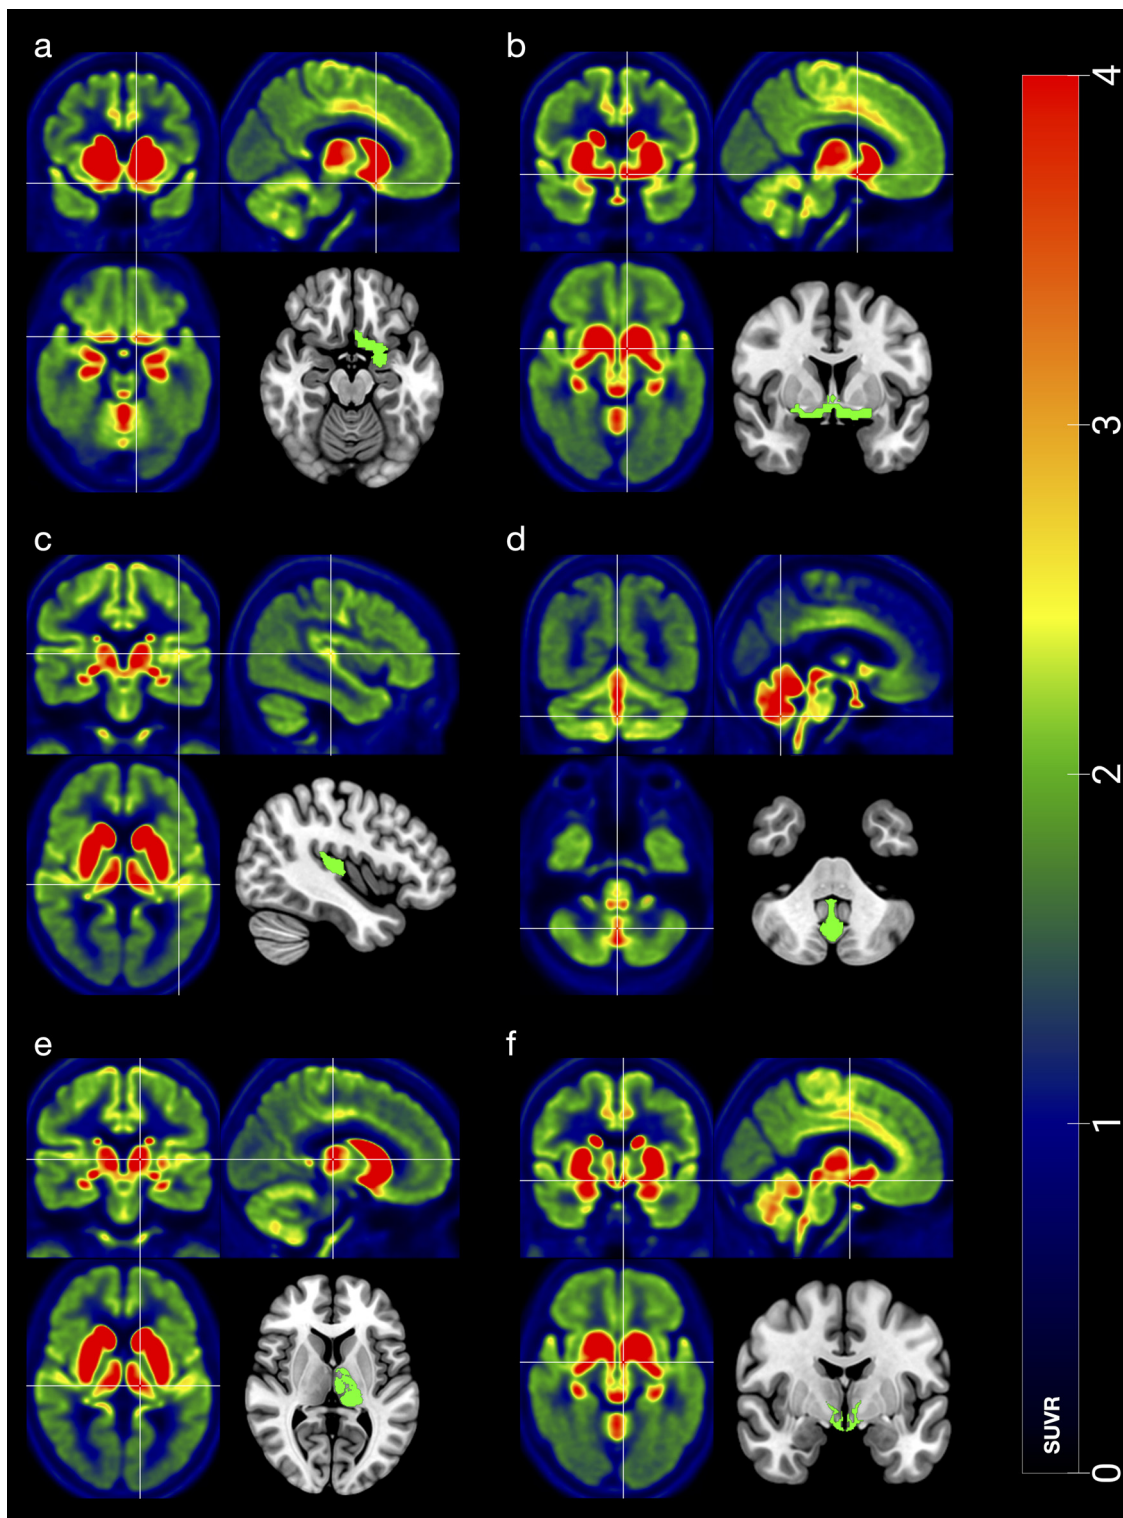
Multi-planar view of selected regions of interest in healthy elderly human brains visualized with $[^{18}\text{F}]$ FEOBV PET. Selected regions are presented as atlas superimposed on MNI templates with corresponding multi planar images generated from $[^{18}\text{F}]$ FEOBV PET averages of healthy elderly human brains. Cross hairs indicate location of (a) olfactory cortex, (b) basal forebrain, (c) Heschl's gyrus, (d) vermis, (e) thalamus, and (f) hypothalamus. Red colour indicates SUVR of 4 or higher.
